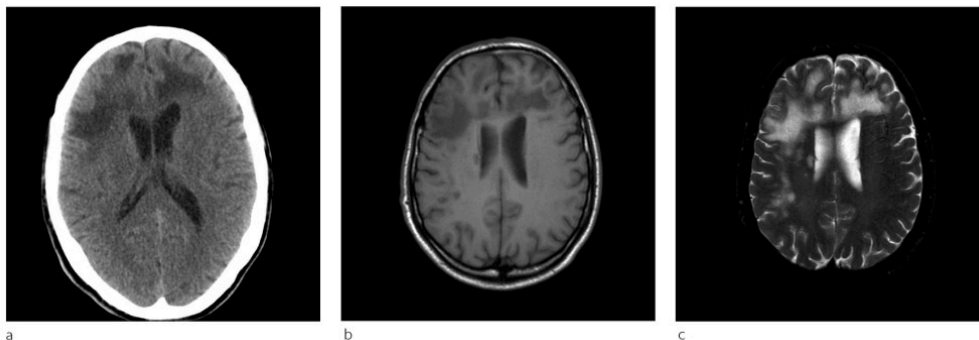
a) In patient 1, CT of the head showed bilateral non-specific confluent hypointensities in frontal subcortical regions. B) T1-weighted MRI series revealed multiple areas with low signal, as in FLAIR series and c) T2-weighted series showed high signal. There was no sign of mass effect and the lesions were not contrast-enhancing.
